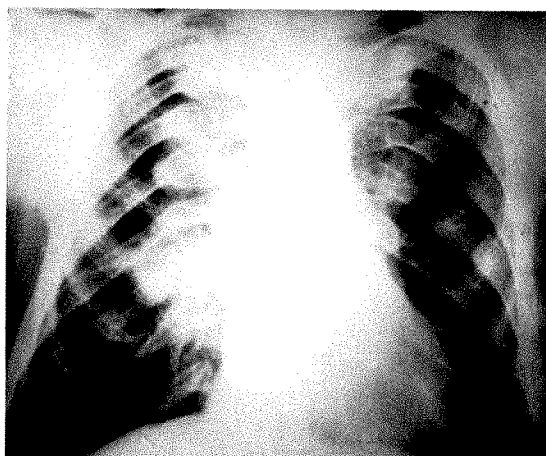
Case 1. Posteroanterior roentgenogram of the chest showing multiple bilateral masses.
